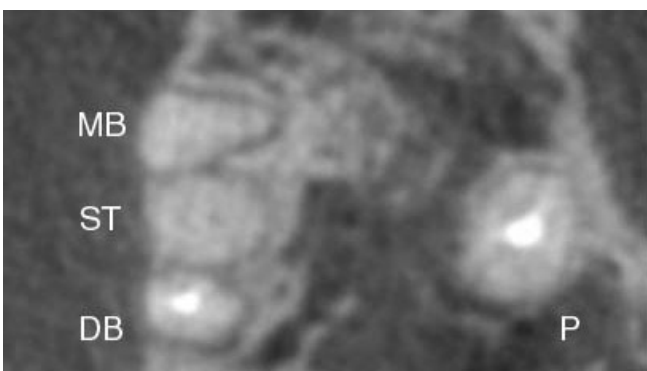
Axial CBCT image of the right permanent maxillary first molar: MB – mesiobuccal root, DB – distobuccal root, P – palatal root, ST – root of the supernumerary tooth.
